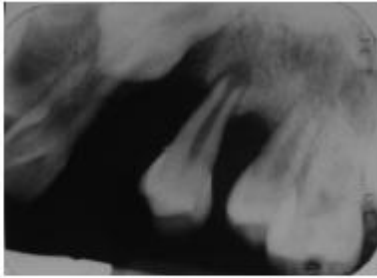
Ten-year-old female with radiographic image of aggressive bone destruction due to a squamous cell carcinoma of the maxillary alveolus.
